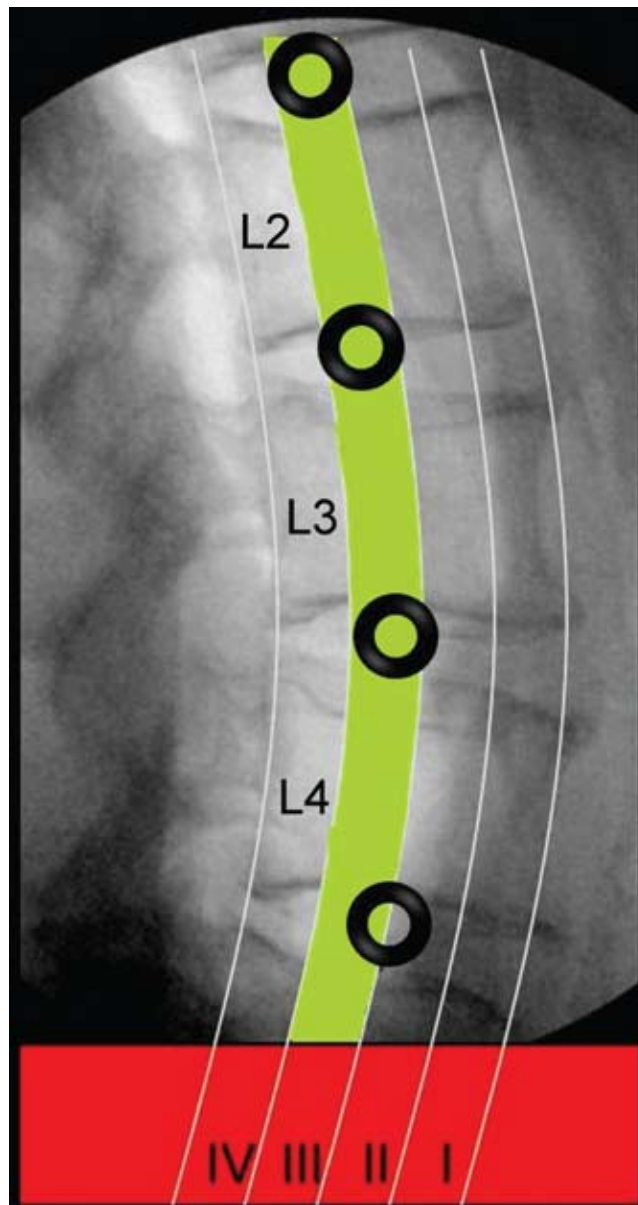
Lateral radiograph of the lumbar spine demonstrating the division of the VB into 4 zones (Zones I–IV) from anterior to posterior. The relative “safe zone” (Zone III) is depicted in green. The recommended safe working zones to prevent direct nerve injury have been indicated with black circles at each level.
